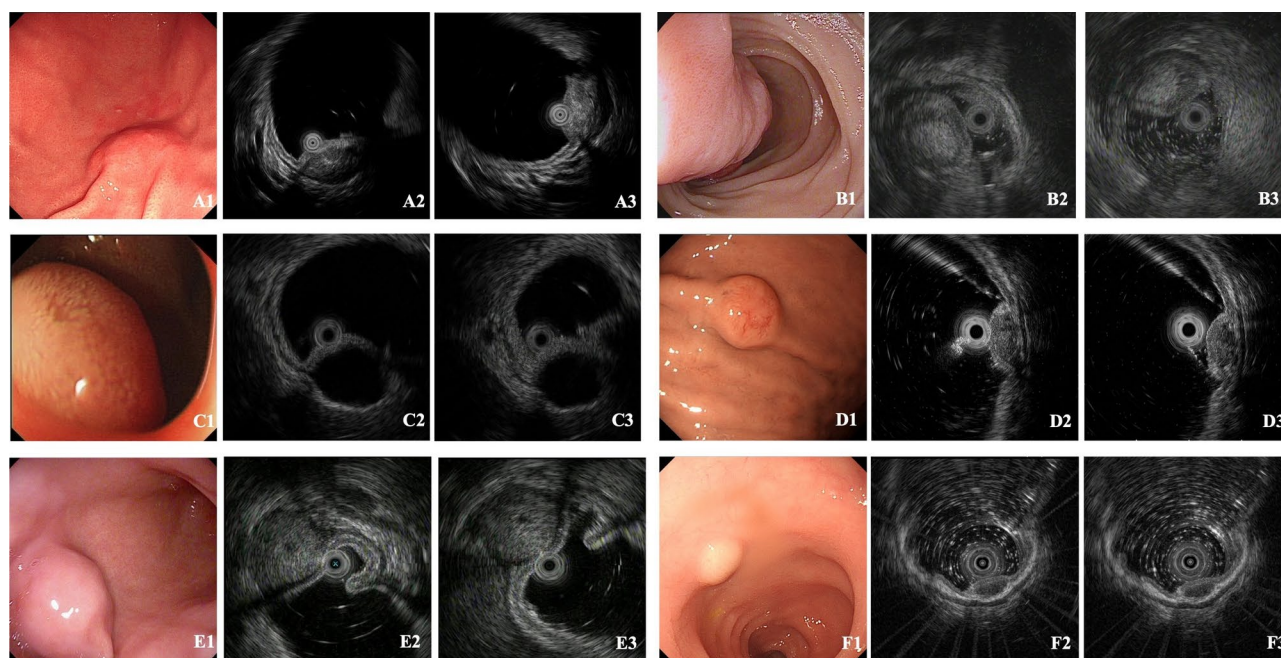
Cases incorrectly classified by microprobe endoscopic ultrasonography. A: Gastric ectopic pancreas incorrectly classified as stromal tumor; B: Duodenal bulb lipoma incorrectly classified as Brunner's gland; C: Duodenal bulb simple cyst incorrectly classified as stromal tumor; D: Gastritis cystica profunda incorrectly classified as ectopic pancreas; E: Gastric glomus tumor incorrectly classified as stromal tumor; F: Rectum paraganglioma incorrectly classified as neuroendocrine tumor
